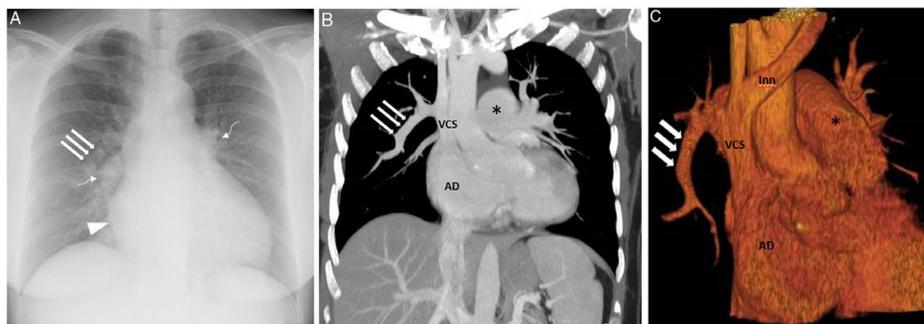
A) Chest X-ray (posteroanterior projection) showing an enlarged right atrium (arrowhead) and an increase in the size and density of both hili (curved arrows); note the presence of a tubular structure in the right lung (straight arrows). B and C) Coronal reconstruction MIP (maximum intensity projection) (B) and 3D (C) images confirming the existence of drainage from the right upper lobe vein to the superior vena cava (straight arrows). Furthermore, the venous return of the middle lobe and several segments of the right lower lobe also drained into this tubular structure. Signs of precapillary pulmonary hypertension with increased pulmonary artery trunk width (asterisk) and secondary RA enlargement are seen. RA: right atrium; Inn: innominate vein; SCV: superior vena cava; RV: right ventricle.
